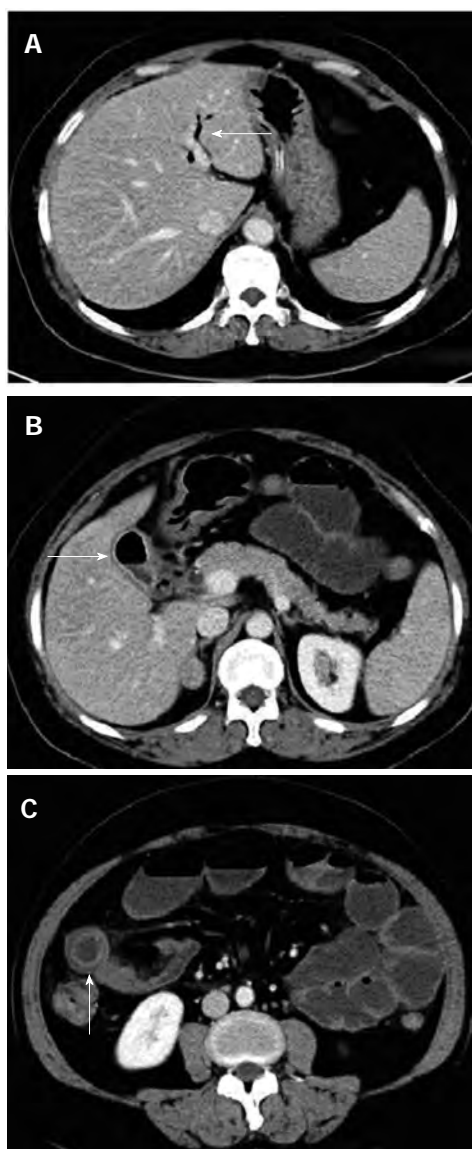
Severe air-fluid level. A: Axial view of the upper abdomen demonstrates air in an intrahepatic bile duct (arrow); B: Axial view of the upper abdomen demonstrates an air in the gallbladder (arrow); C: Computed tomography demonstrating gallstones of approximately 5 cm in diameter (arrow) within the small bowel.
